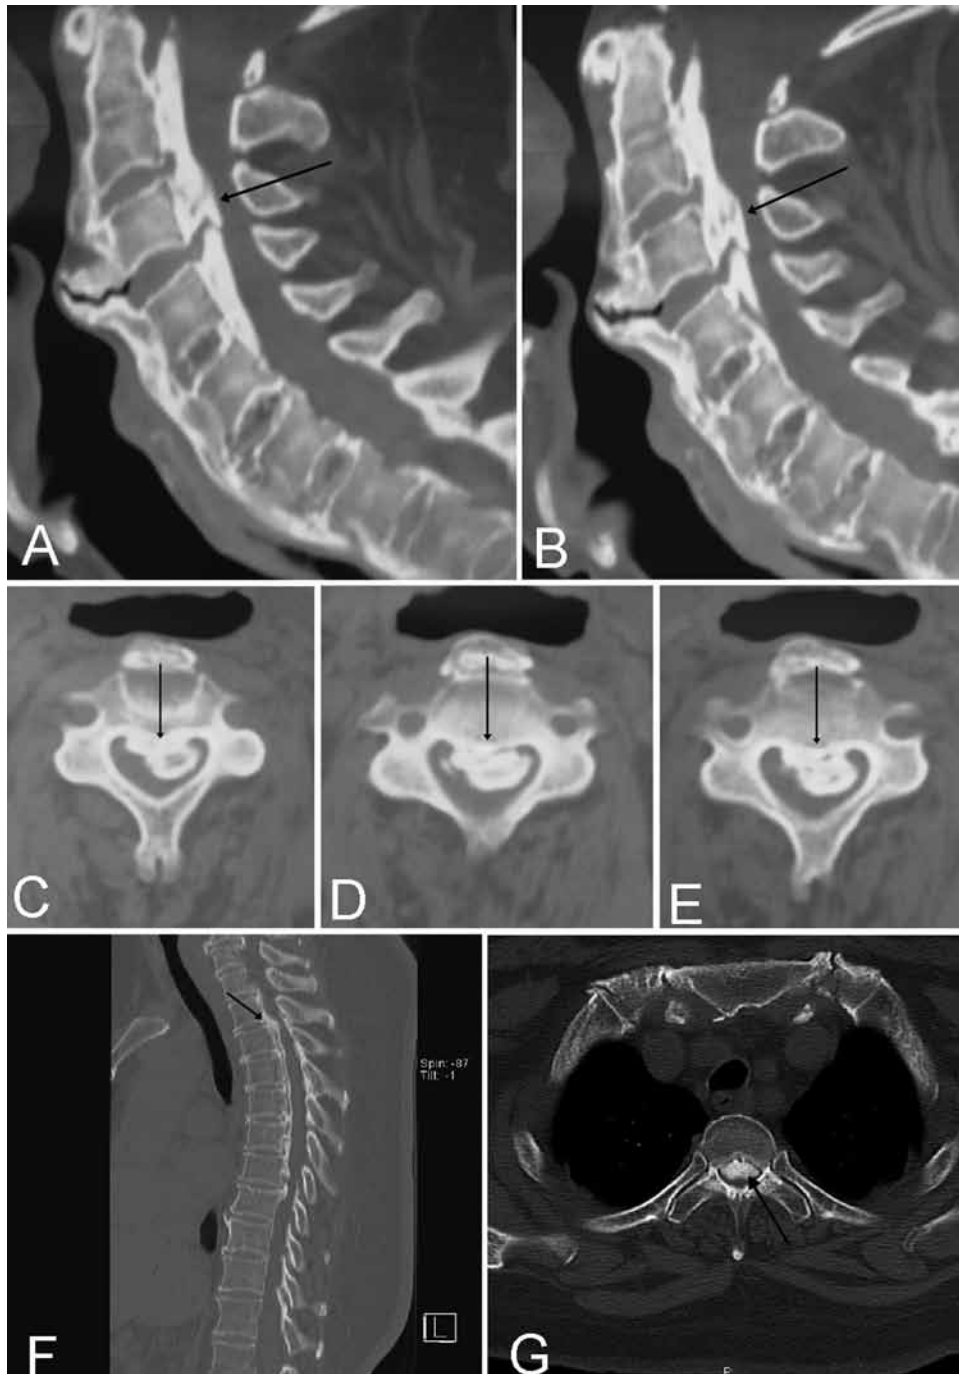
Computed tomography scans showing OPLL in different locations. A and B: Sagittal reconstructed images show large OPLL at C2–5 (arrow). C–E: Axial images of the cervical spine show a large OPLL occupying more than 50% of the spinal canal (arrows). F: Sagittal reconstructed image of the thoracic spine shows a mixed-type OPLL. The spinal canal is narrowest at T2–3 (arrow). G: Axial CT image shows large a OPLL occupying more than 80% of the spinal canal (arrow).
